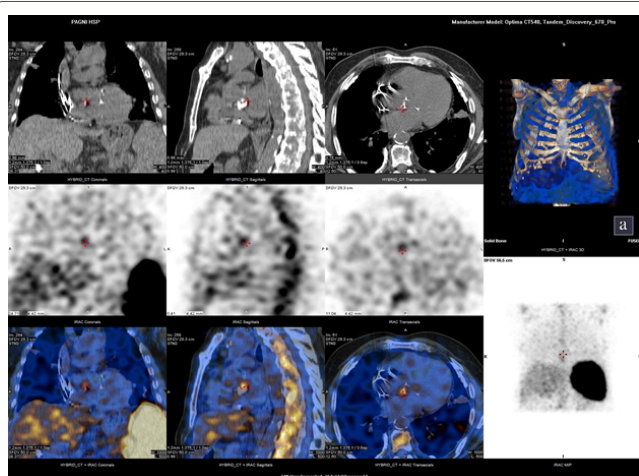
Radiolabelled Leucocyte Scintigraphy. ^{99m}Tc-HMPAO-WBC scintigraphy revealed the presence of CIED-associated infection.
